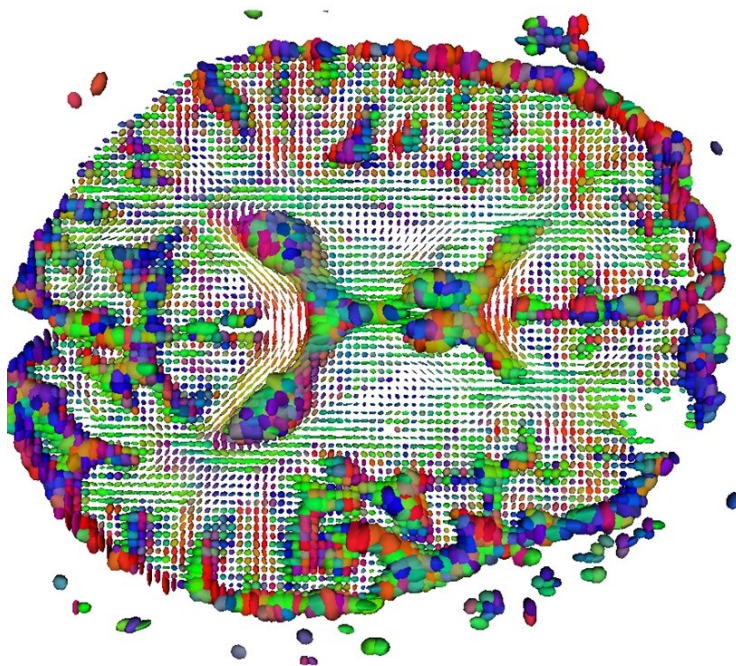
Slice of the tensor field estimated from DWI of Fig. 1.4 with classical techniques. We notice that the field looks rather noisy, and even some parts of it are missing (bottom right corner of this slice) due to distort of the acquisition.
